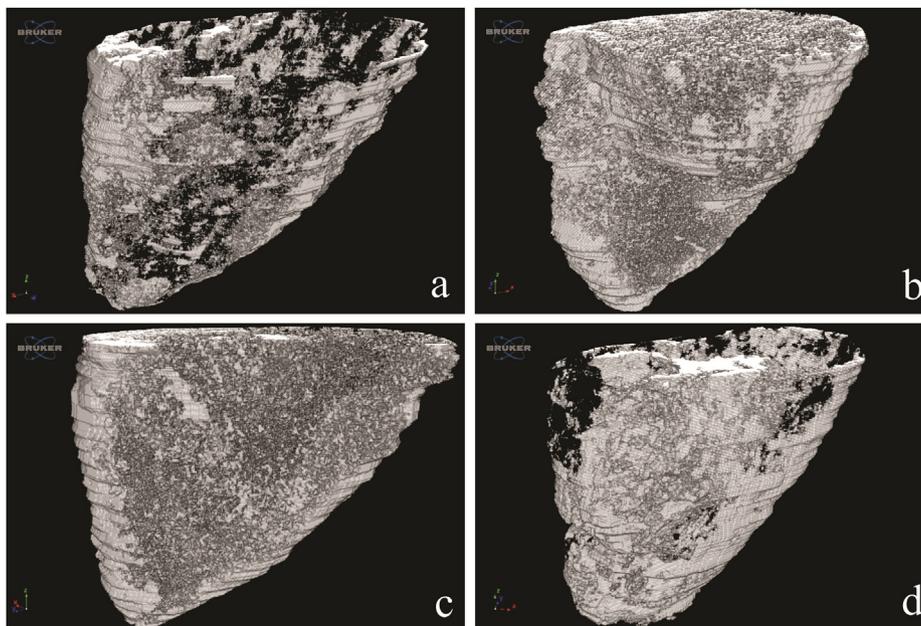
Three-dimensional image of the alveolar socket from micro-computed tomography (μ CT) analysis (ventral view). The hyperdense areas show mineralized bone. a = control, b = alendronate, c = ethyl acetate extract, d = ethanol extract.
